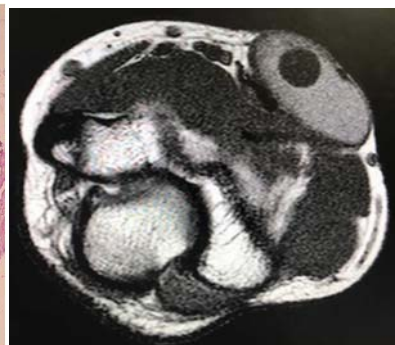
MRI showing cyst with scolex
